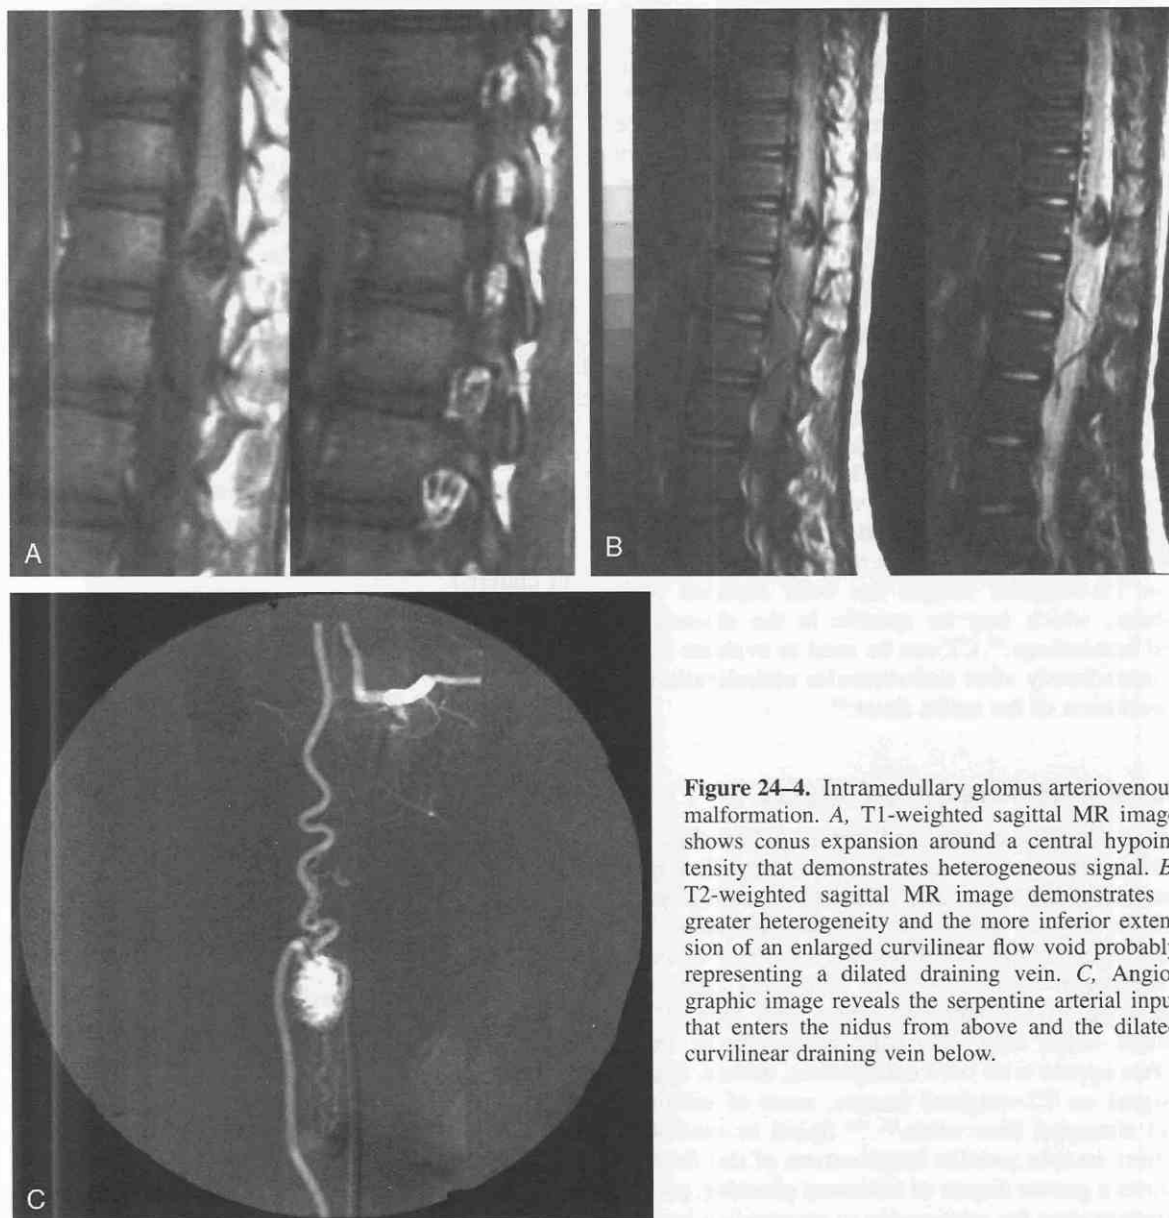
Intramedullary glomus arteriovenous malformation. A, T1-weighted sagittal MR image shows conus expansion around a central hypointensity that demonstrates heterogeneous signal. B, T2-weighted sagittal MR image demonstrates a greater heterogeneity and the more inferior extension of an enlarged curvilinear flow void probably representing a dilated draining vein. C, Angiographic image reveals the serpentine arterial input that enters the nidus from above and the dilated curvilinear draining vein below.
